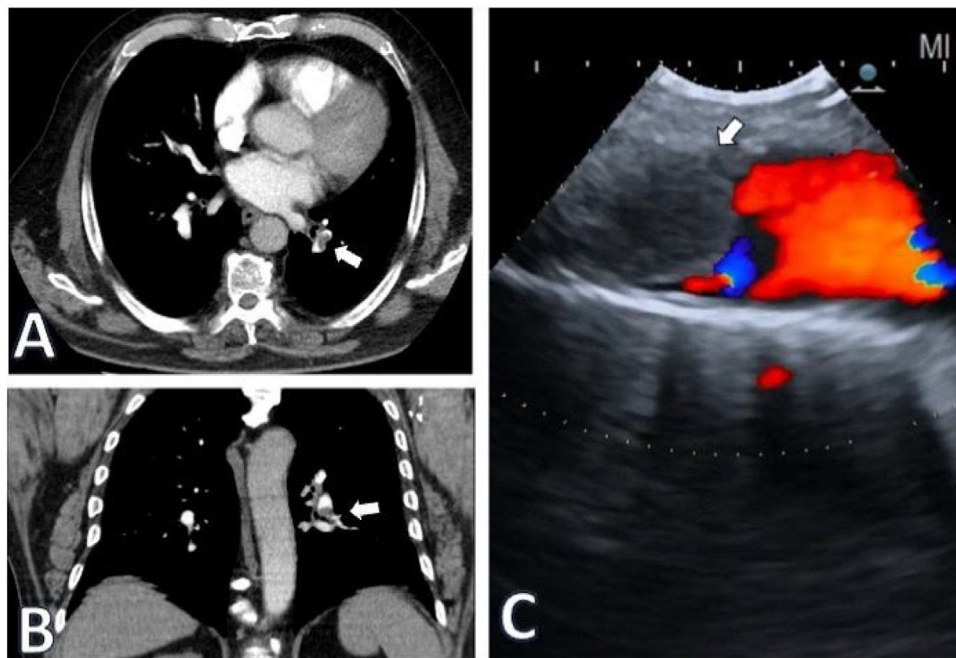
Images of the thrombus in the left pulmonary artery branch, indicated by the arrow, in axial (A) and coronal (B) sections of CTPA. (C) EBUS: Doppler mode image showing the thrombus occluding the arterial circulation.
